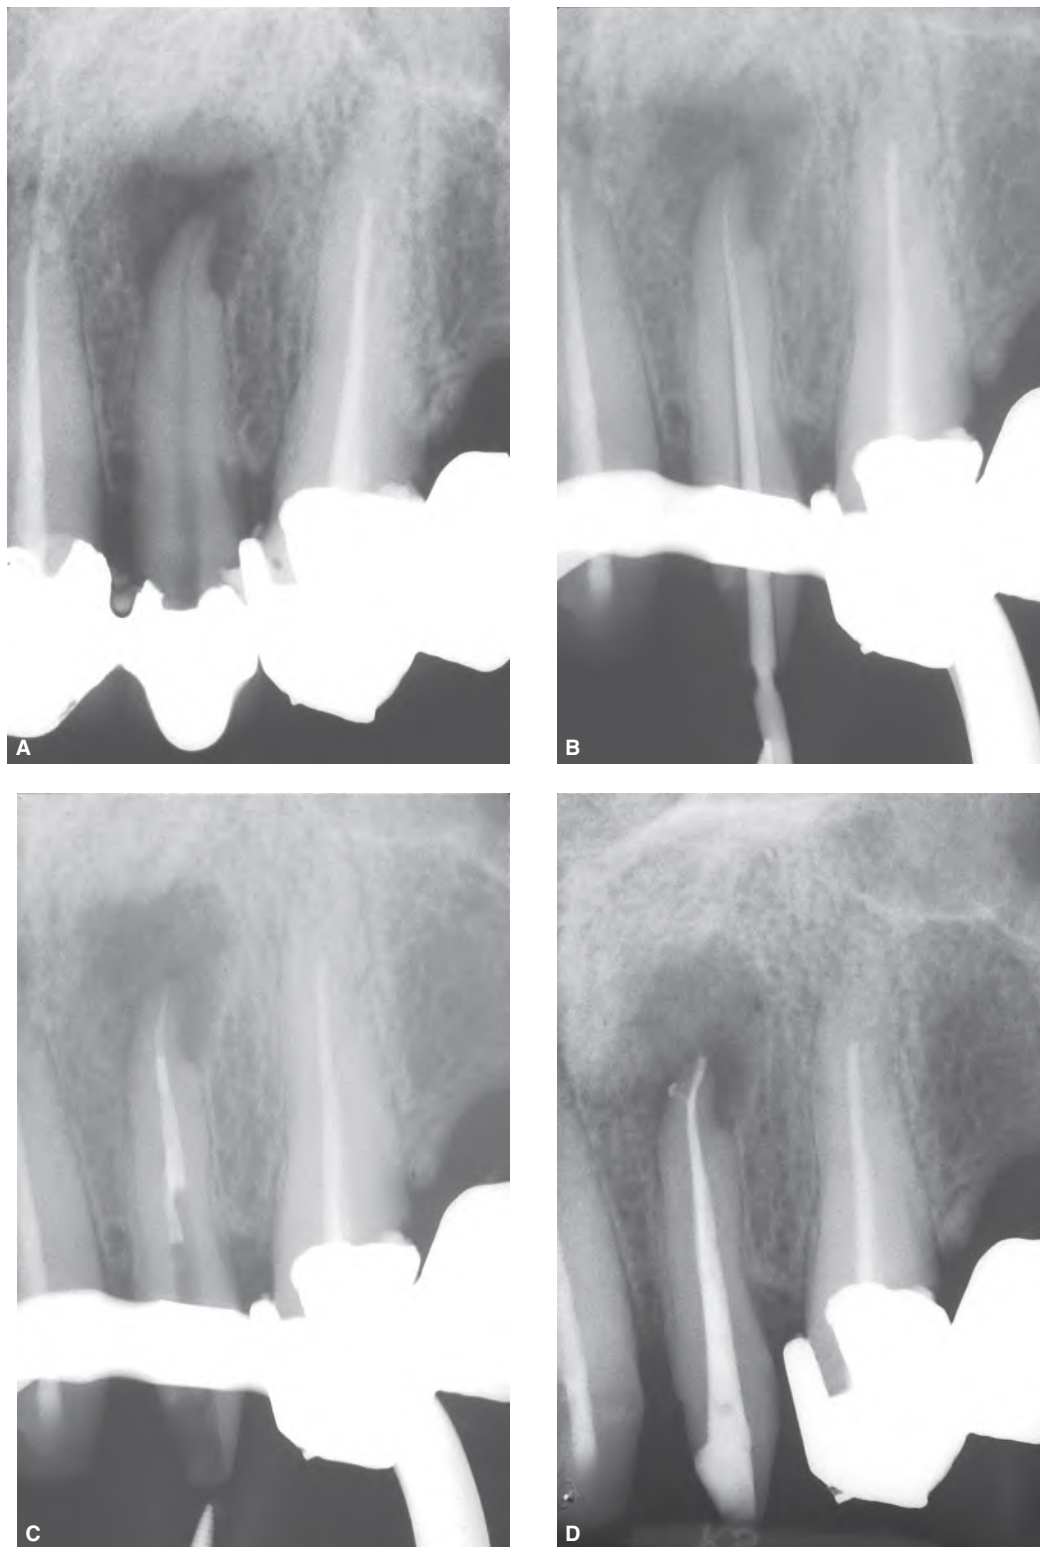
A.* Preoperative radiograph of maxillary left lateral incisor. *B.* Intraoperative radiograph of the cone fit. *C.* Radiograph of the apical compaction. The gutta-percha appears to be compacted for about 4 mm and then seems to fold. This is because the material has not been modified in the most apical portion. It is necessary to advance more apically with the heat-carrier and better compact the gutta-percha. *D.* Postoperative radiograph showing the obturation material being homogeneous and well compacted. The presence of a lateral canal has also been demonstrated by the filling material.
